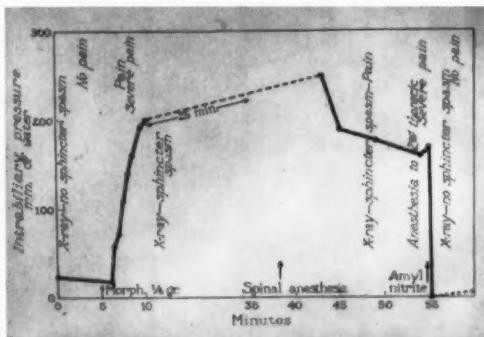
This graph shows the intrabiliary pressure taken through a T-tube. Following subcutaneous injection of morphine sulfate there was an increase in intrabiliary pressure due to spasm of the sphincter of Oddi, as demonstrated by x-ray. Biliary pain occurred from increased intrabiliary pressure. Pain or spasm was not relieved by spinal anesthesia. Pain, spasm, and intrabiliary pressure were relieved by amyl nitrite.
